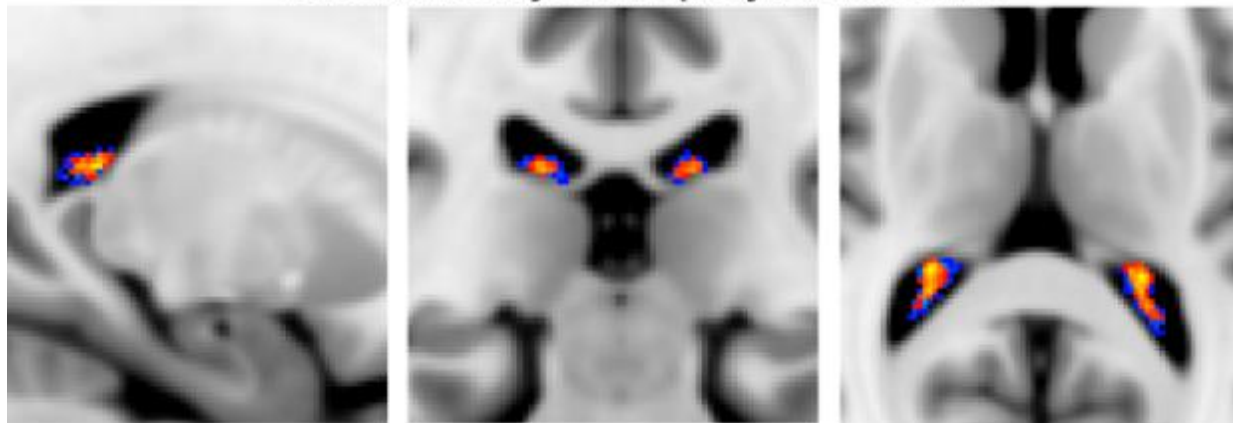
Changes in the volume of the choroid plexus of the lateral ventricles (A.) and in signal intensity (B.) in iRBD compared to elderly controls (n=12) using 7 Tesla multi-contrast MRI. In iRBD we observed decreased volume in right choroid plexus, trends in left choroid plexus volume and longer T₂*-weighted values, and no changes in T₁-weighted values. These results are compatible with atrophy of the choroid plexus in iRBD. We are currently analyzing multi-contrast 7 Tesla data of a larger cohort to further elucidate the choroid plexus role in the pathogenesis and progression of synucleinopathies.
